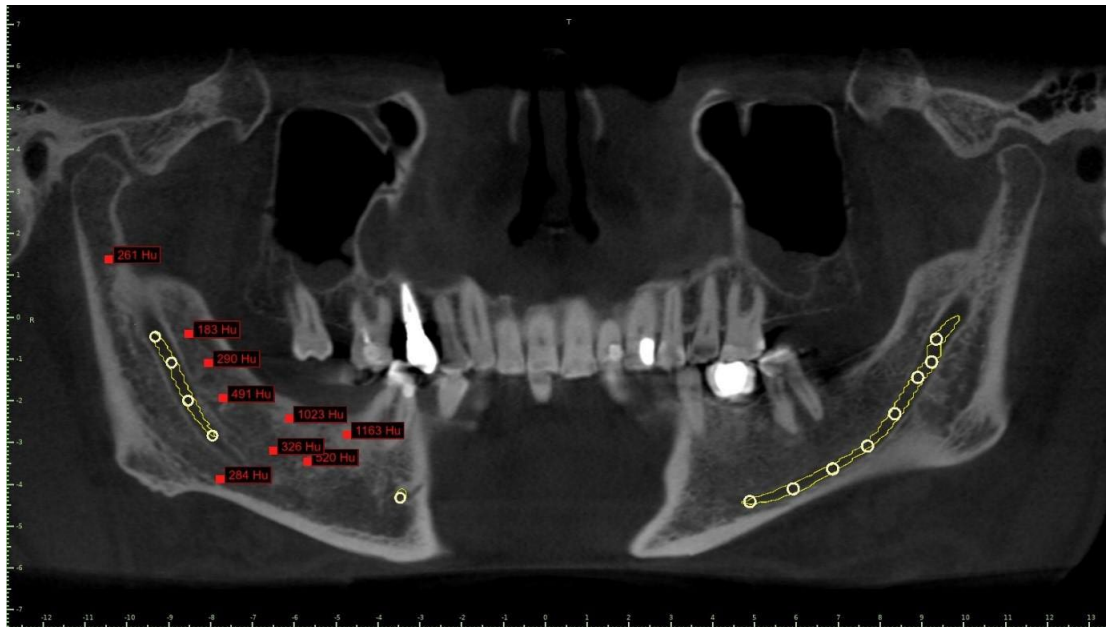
Conical Haz Computed Tomography for evaluation of bone density in HU
